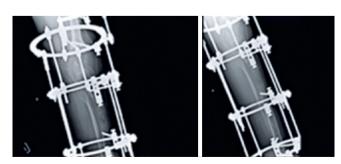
Internal and external oblique radiographs of the knee and right leg show bone regeneration in the formation process in the proximal third of the tibia after outpatient follow-up.
